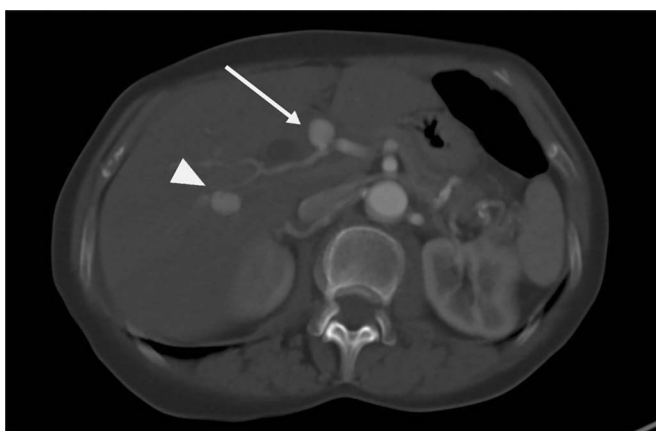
Axial contrast-enhanced computed tomography shows left hepatic artery aneurysm (arrow) and right hepatic artery aneurysm (arrowhead).
